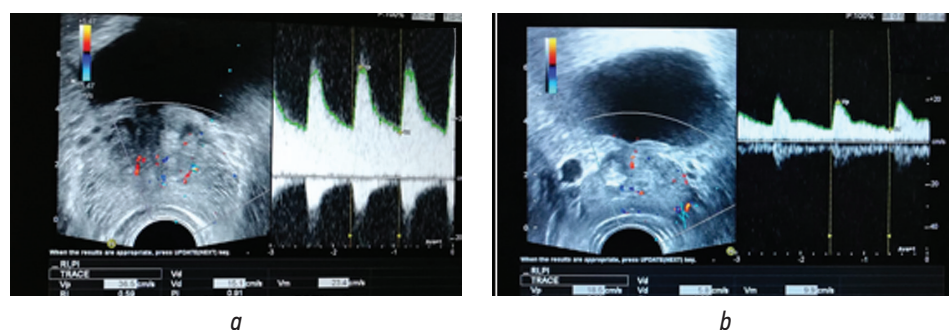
Patient P. (main group). Doppler TRUS of the prostate after treatment at visit 3: *a* – urethral branches of the prostate artery; *b* – capsular branches of the prostate artery
